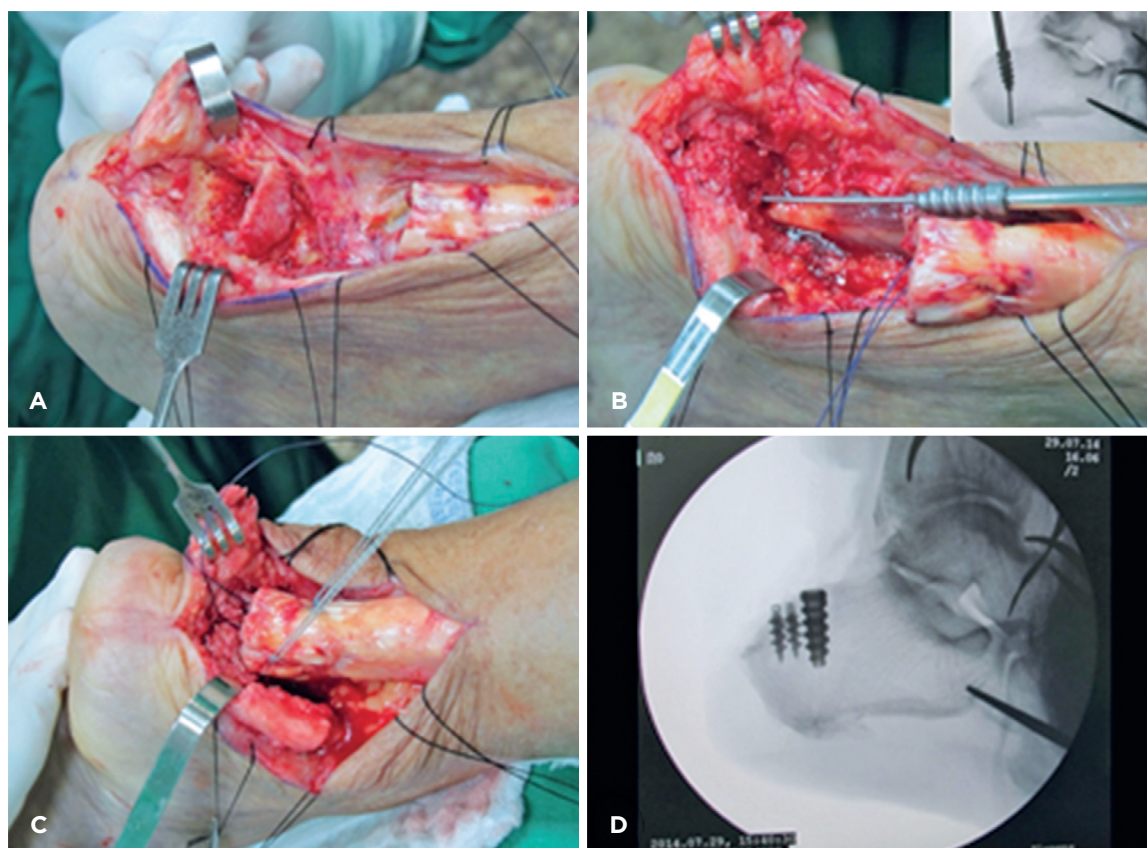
Central posterior approach to the Achilles Tendon. A) with resection of affected tendon, bone spurs, and Haglund's prominence; B) Preparation to flexor hallucis longus tendon transfer with interference screw; C) reattachment of the Achilles tendon with two double-row bone anchors; D) Lateral radiograph showing the position of the anchors and the interference screw in the calcaneus.
